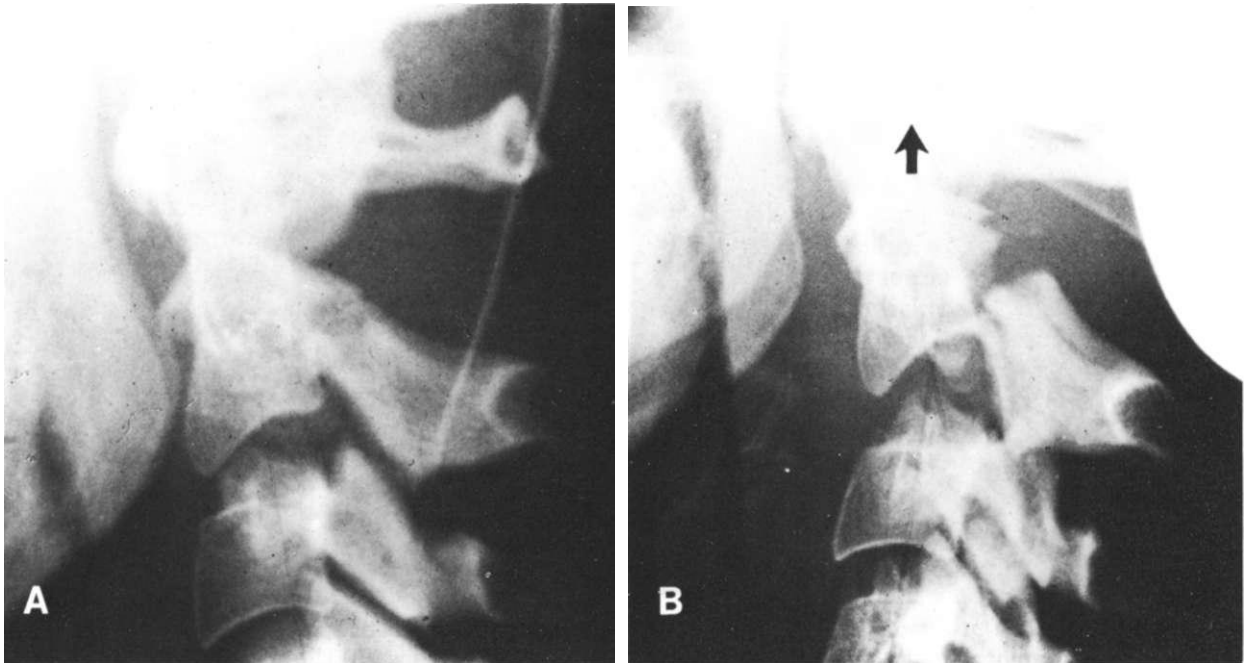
Radiographs of an adult in an automobile accident. (A) The patient in a resting position. (B) The patient after the application of 8 kg of axial traction. The separation of the anterior elements is dramatically demonstrated. Note that there is little change in the relationships of the posterior elements. The implication is that the ligamentous structures are intact posteriorly. They were not ruptured by tensile loading at the time of injury, as were the anterior elements. This fits with the presumed mechanism of injury; the posterior elements were under compression at the time of failure. (Courtesy of Dr. Mason Hohl, Beverly Hills, Calif.)
